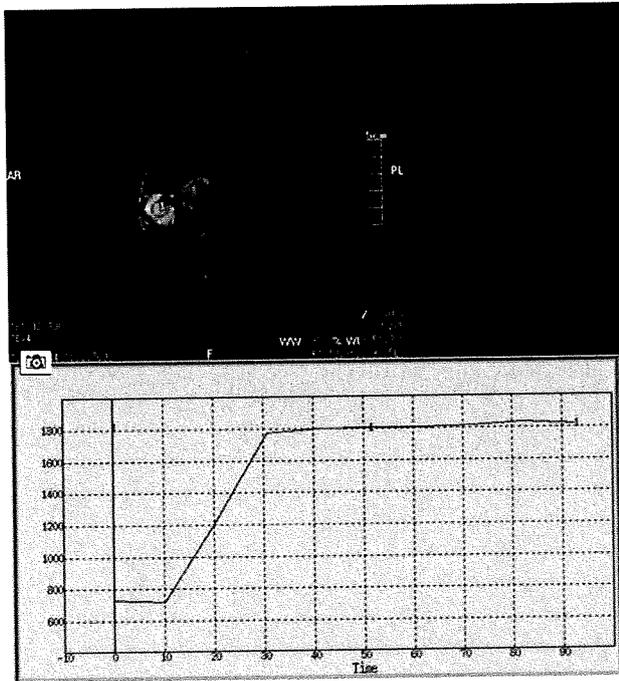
Dynamic magnetic resonance imaging showed malignant patterns in the time-intensity curve of the lesion
